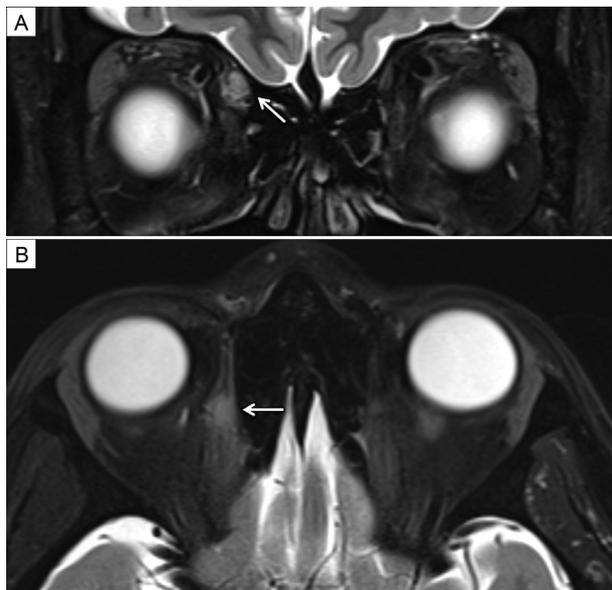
Coronal (A) and axial (B) T2-weighted fat-suppressed magnetic resonance images demonstrating mildly expansile T2 hyperintensity within the right superior oblique muscle belly consistent with edema (arrow). And a $3 \times 2 \times 4$ mm (anterior-posterior \times transverse \times sagittal) rim-enhancing focus with intermediate T2 signal with minimal extraconal fat stranding.
